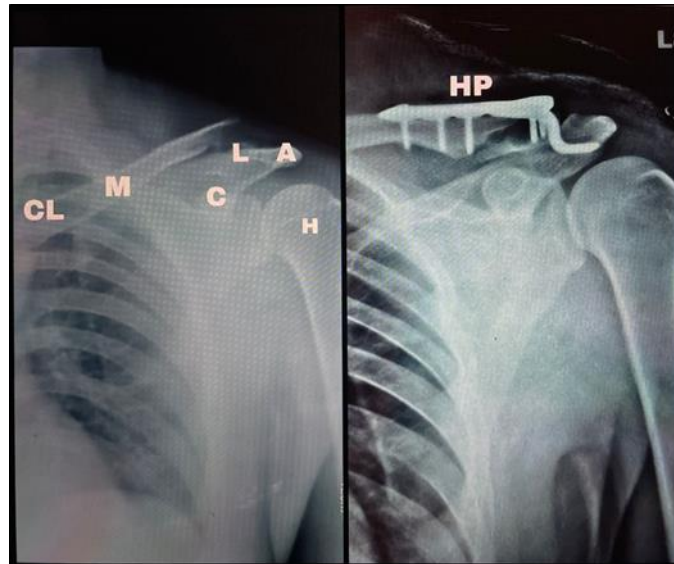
Pre-op and immediate post op x-rays following ORIF with clavicle Hook plate and screws. CL- Clavicle, L-Lateral fracture segment, M-medial fracture segment, C-Coracoid process, A-Acromion, HP-Clavicular Hook plates, H-Humerus, A-Acromion
